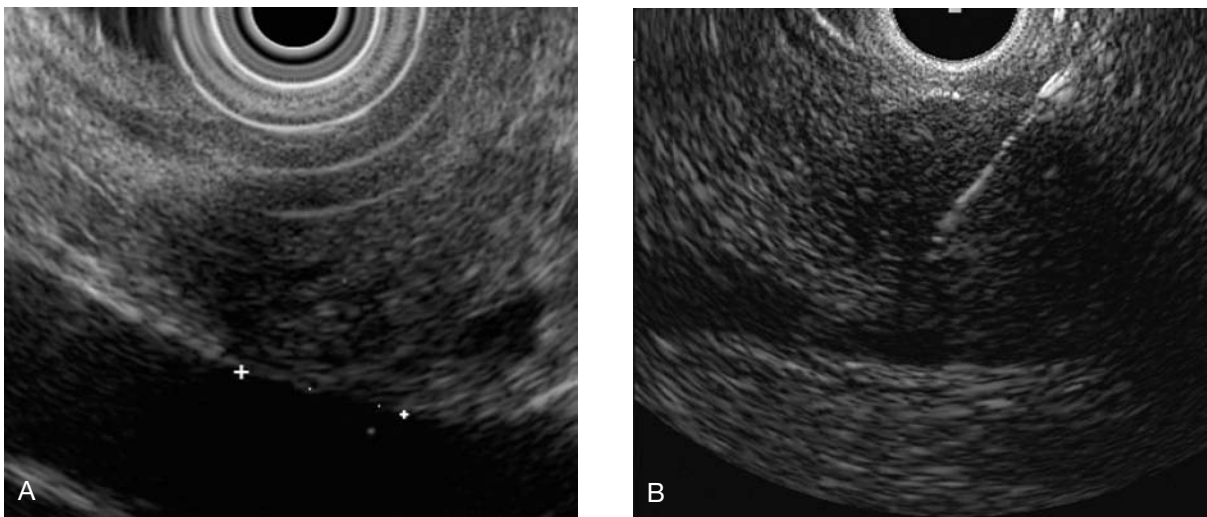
A, Endoscopic ultrasonogram of the pancreatic head shows a poorly defined hypoechoic mass that impinges on the portal vein for a distance of 11 mm (see markers). Surgical resection confirmed invasion of the portal vein. B, Fine-needle aspiration of mass shown in A.
